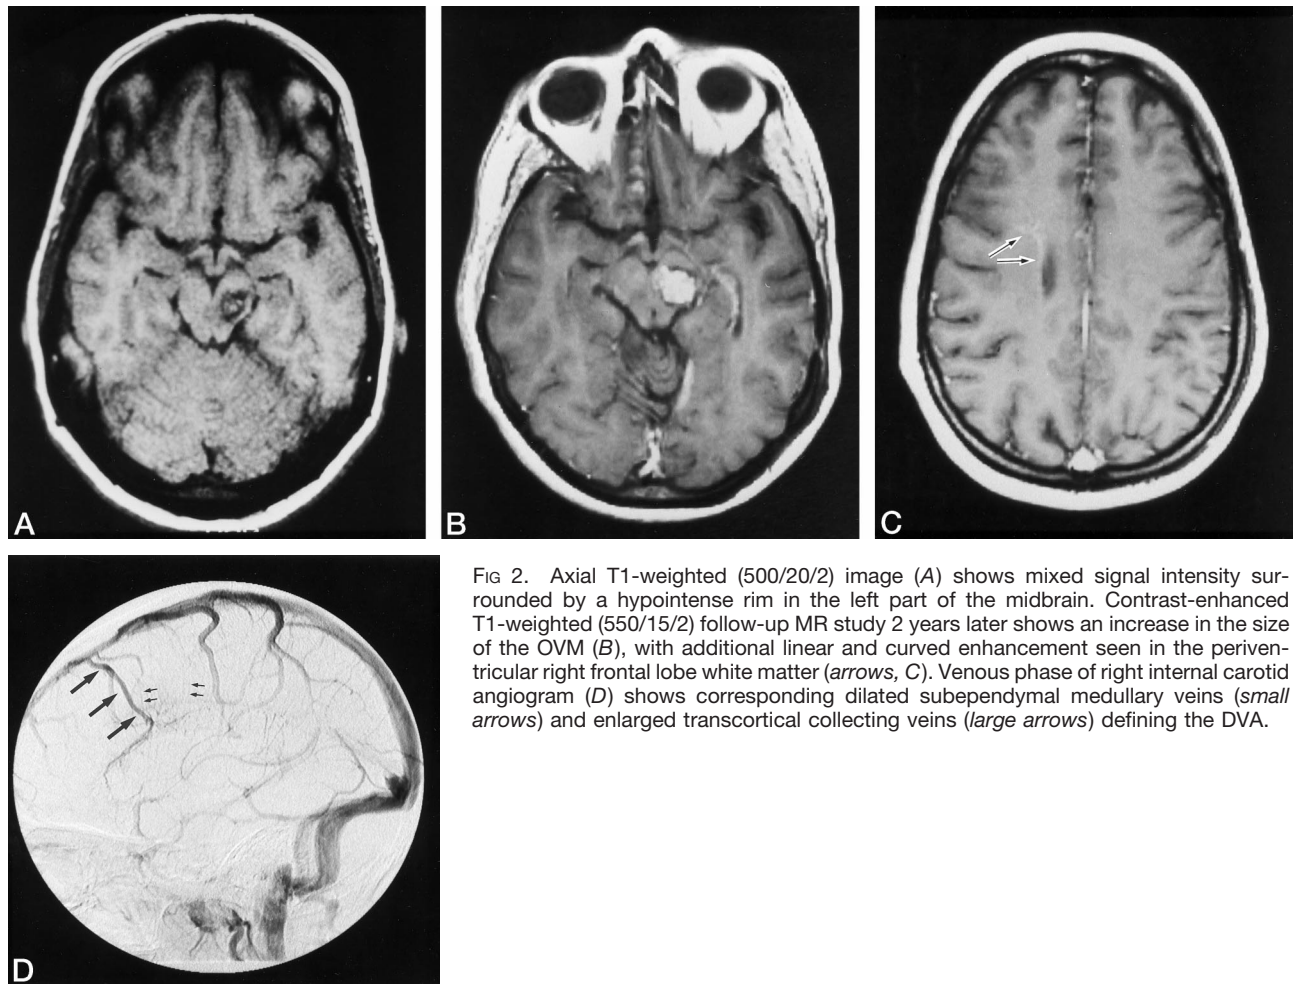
Axial T1-weighted (500/20/2) image (A) shows mixed signal intensity surrounded by a hypointense rim in the left part of the midbrain. Contrast-enhanced T1-weighted (550/15/2) follow-up MR study 2 years later shows an increase in the size of the OVM (B), with additional linear and curved enhancement seen in the periventricular right frontal lobe white matter (arrows, C). Venous phase of right internal carotid angiogram (D) shows corresponding dilated subependymal medullary veins (small arrows) and enlarged transcortical collecting veins (large arrows) defining the DVA.
